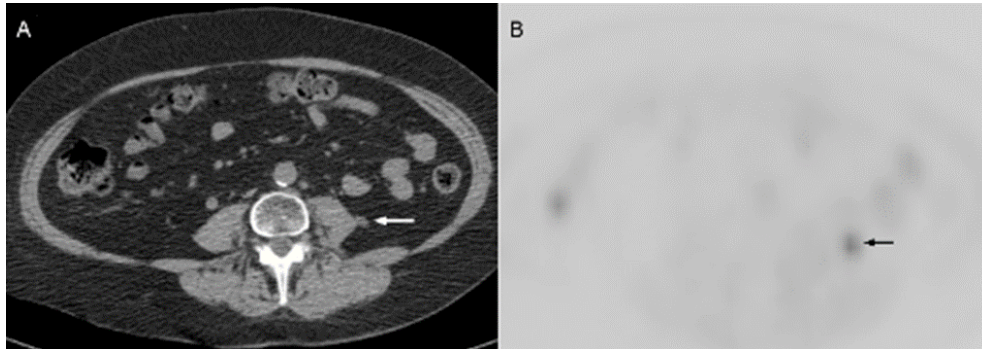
PET/CT scan: A. Axial unenhanced CT image of the abdomen demonstrates a recurrent soft tissue mass (white arrow) abutting the left psoas muscle. B. Axial PET image demonstrates hyper metabolism within a mass (black arrow) along the left psoas muscle.
